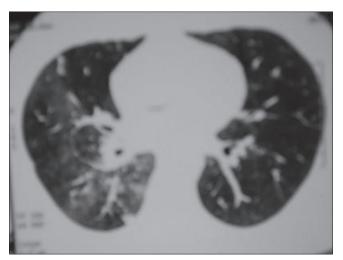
High-resolution computed tomography chest of the case of systemic lupus erythematosus showing ground glass haze with thickening of the central interstitium on right side
